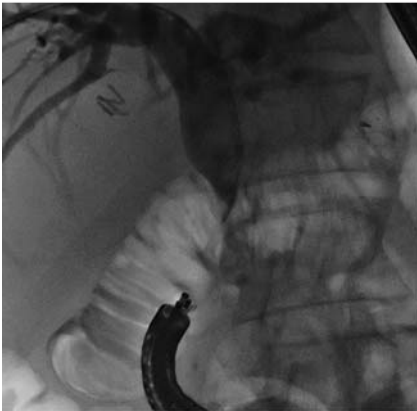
Abdominal radiograph showing occlusion of the common bile duct with the endoscope in position at the level of the afferent limb.
